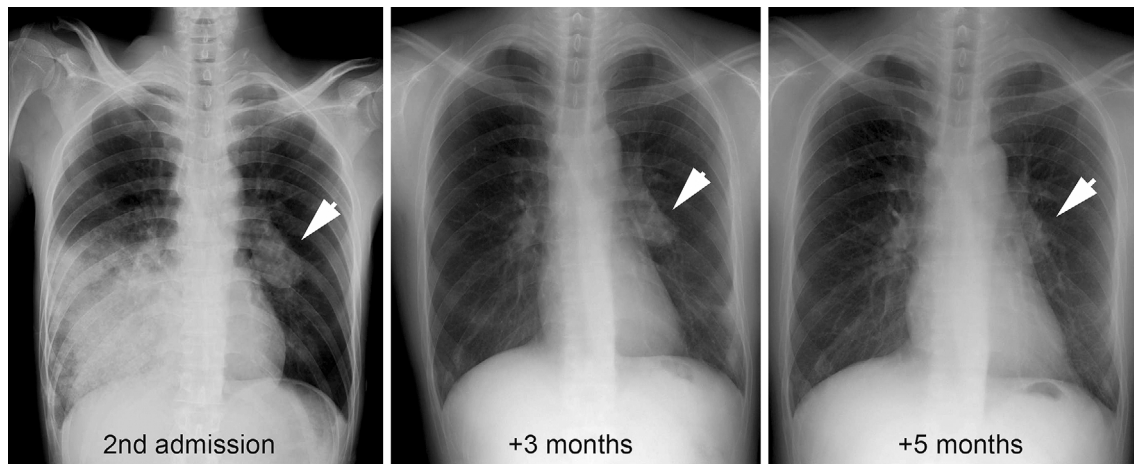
Resolution of the pulmonary artery aneurysms. At second admission, chest X-ray showed consolidation in the right lower lung field (left). The left pulmonary artery aneurysm (arrows) had shrunk in size at 3 months after beginning therapy with corticosteroids and cyclophosphamide. The aneurysm appeared to be resolved at the end of the cyclophosphamide pulse therapy regimen, which was five months after starting treatment.
